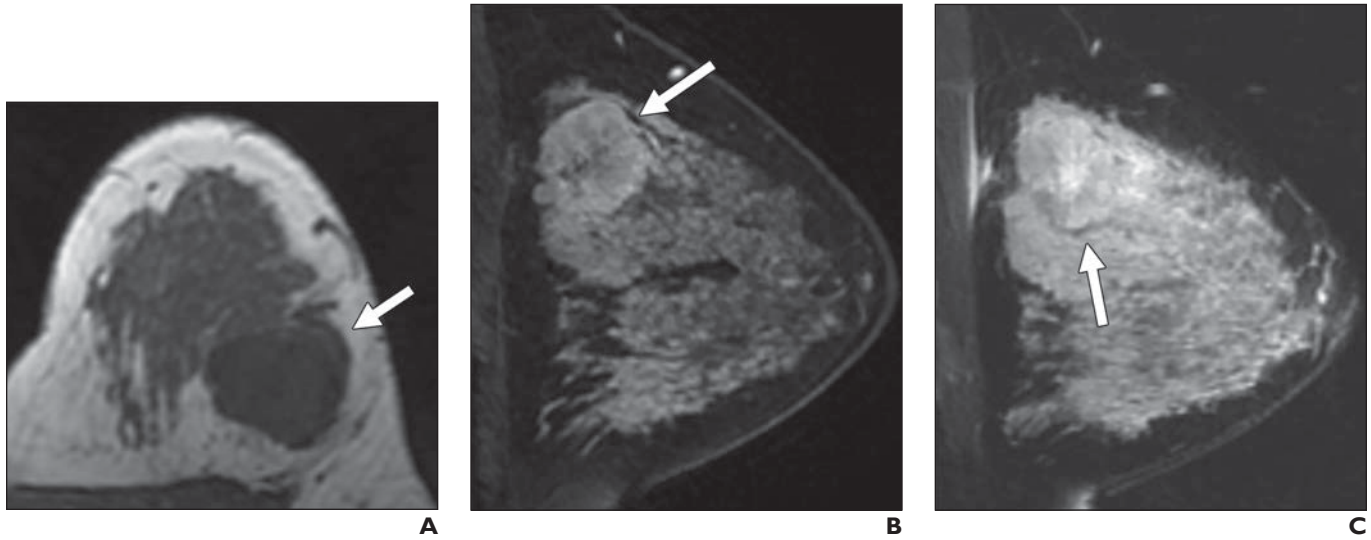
34-year-old woman 2 months postpartum who presented for staging MRI after diagnosis of invasive ductal carcinoma.
